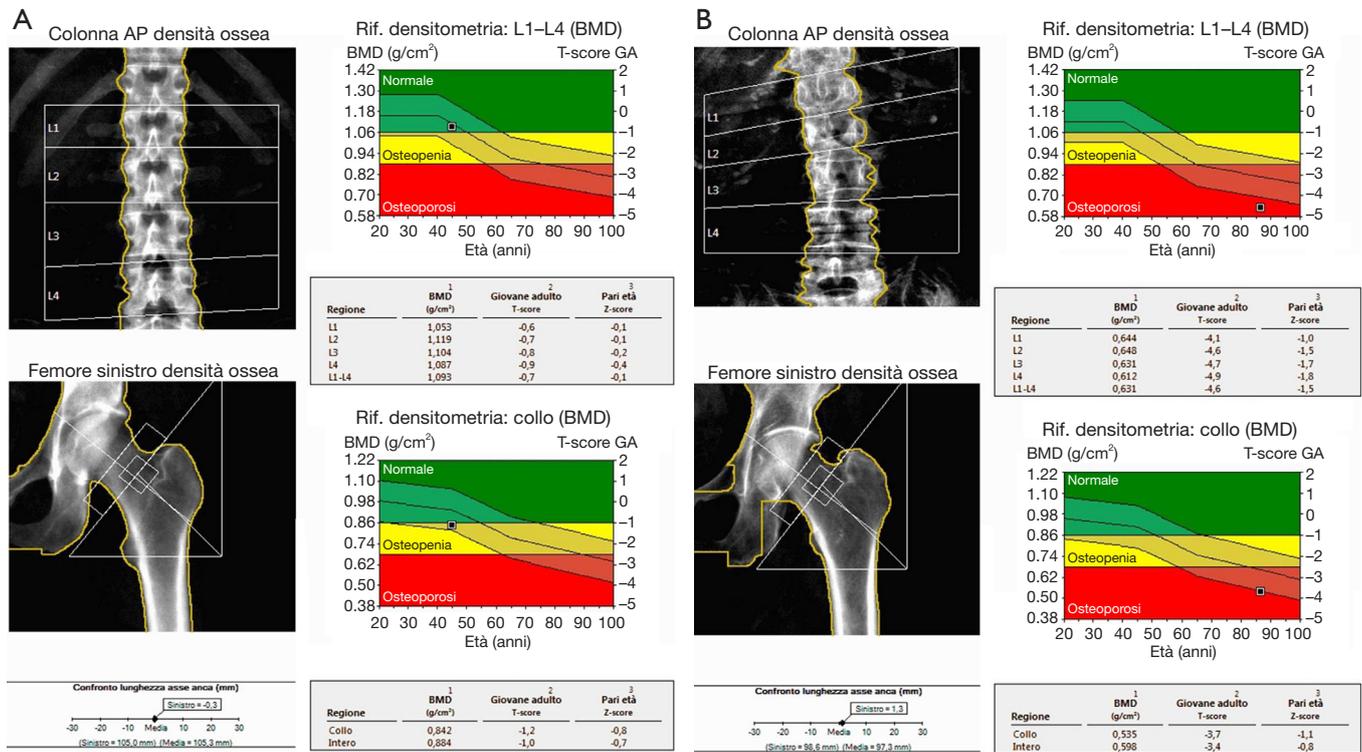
DXA examination. (A) Normal lumbar and femoral DXA; (B) pathological lumbar and femoral DXA. DXA, dual-energy X-ray absorptiometry; BMD, bone mineral density.
